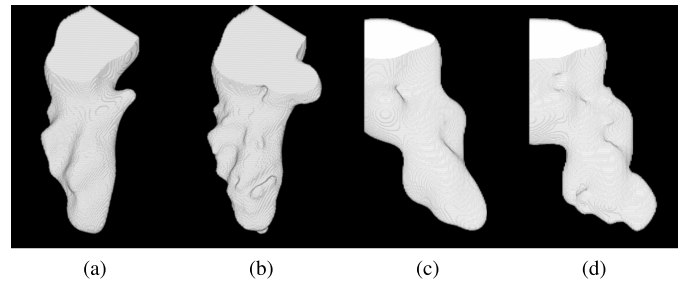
Segmentation and interpolation of large gaps and small angle between the images and the modeled object's surface – the modeled objects are the LV cavity of a heart from sets of parallel long-axis CT-scan slices. Gap size: (a) and (b) 15 pixels, (c) and (d) 20 pixels. Reconstruction by, left column: the small object or hole preserving approach ( $\gamma = 3$  then (a)  $\gamma = 9$ , and (c)  $\gamma = 12$ ), and right column: the surface-detail preserving approach ( $\gamma$  ranging from 3 to (b) 12, and (d) 15).
